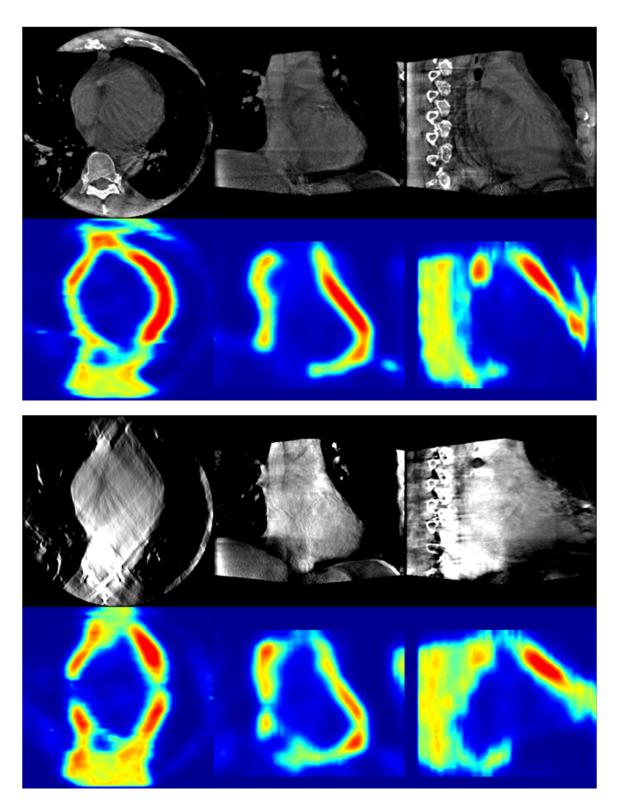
Top: slices of volume reconstructed using regular 3D C-arm CT protocol (200 degrees) and corresponding probability map, bottom: slices of Tomosynthesis volume (90 degree C-arm sweep) and corresponding probability map
